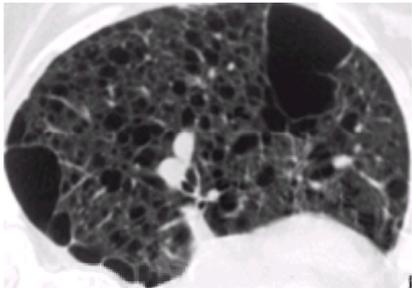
Lymphangioleiomyomatosis. CT in a 44-year-old woman with LAM demonstrates multiple, thin-walled cystic radiolucencies bilaterally. Note the two large lesions, representing confluent cysts.
